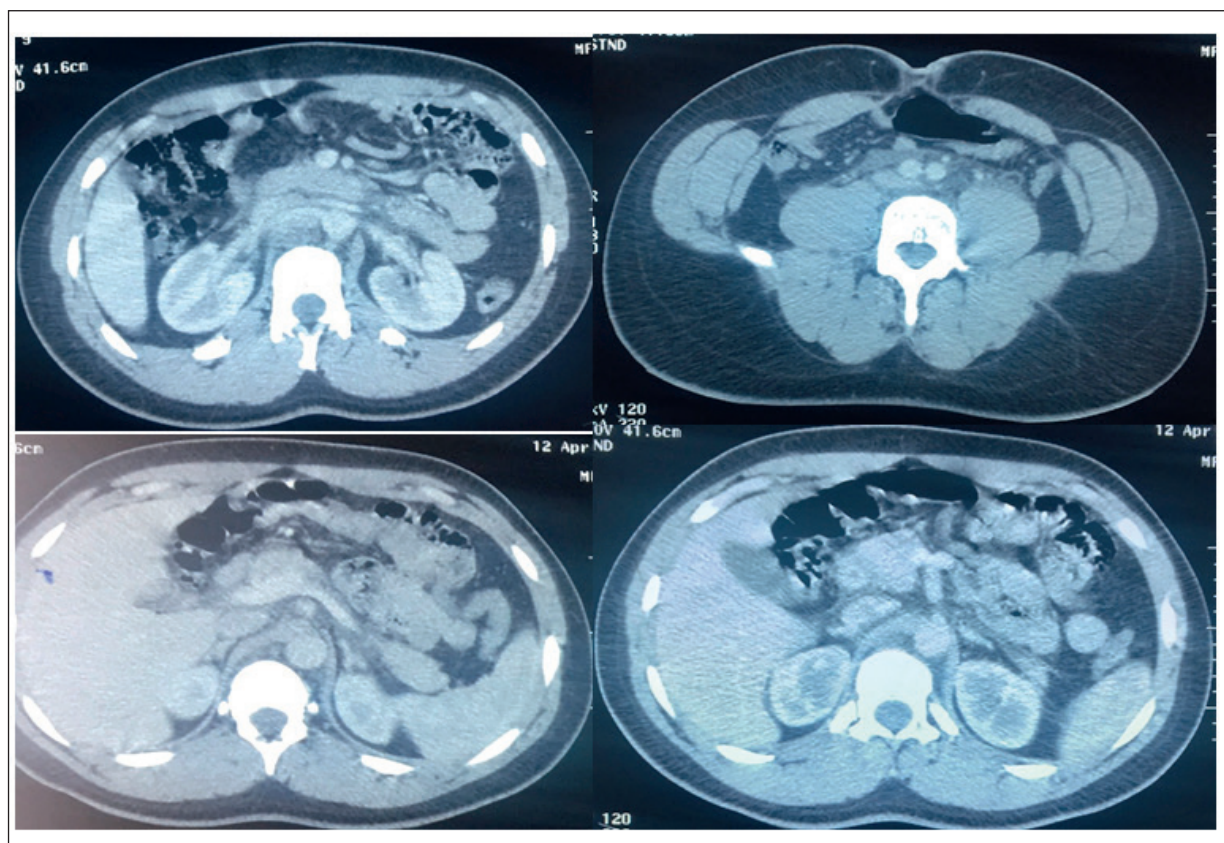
Transverse CT scan of the abdomen showing a high-density lesion within the retroperitoneal space.
